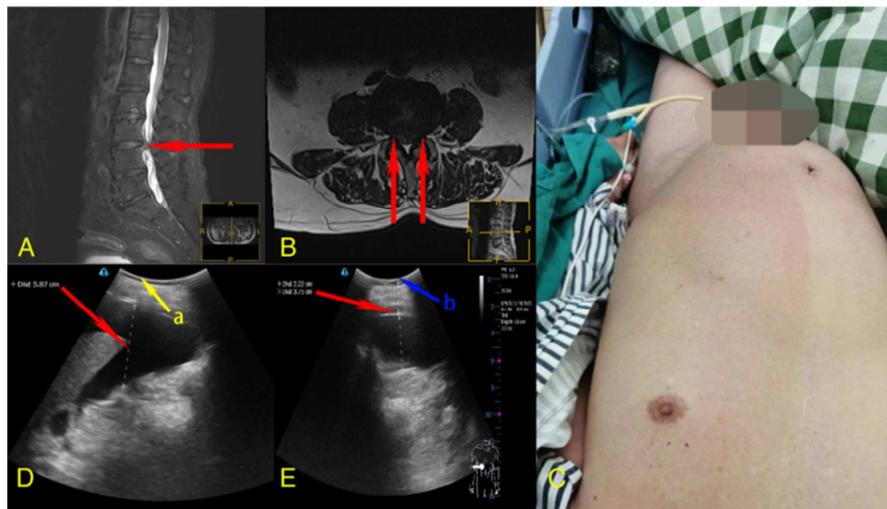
A. Sagittal MRI of the lumbar spine: shows L3-L4 disc degeneration with severe posterior intraspinal disc herniation and compression of the thecal sac and cauda equina. B. MRI Axial view: slices through L3-L4 disc showed central left protrusion of disc in posterior spinal canal and narrowing of foramina on both sides. C. After changing position to supine position, the patient was found to have cyanosis of both lower extremities and very high abdominal tone. D. Anchor point a is lower, this point corresponds to the liquid area 20 mm away from the body surface, and the anteroposterior diameter of dark area is 59 mm. E. Anchor point b is relatively superior, this point corresponds to liquid area 22 mm far away from body surface, and the anteroposterior diameter of dark area is 38 mm.
